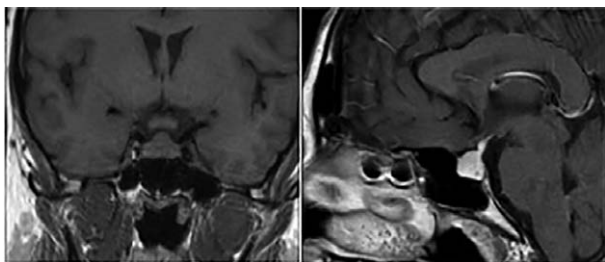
Pretreatment pituitary MRI image.
